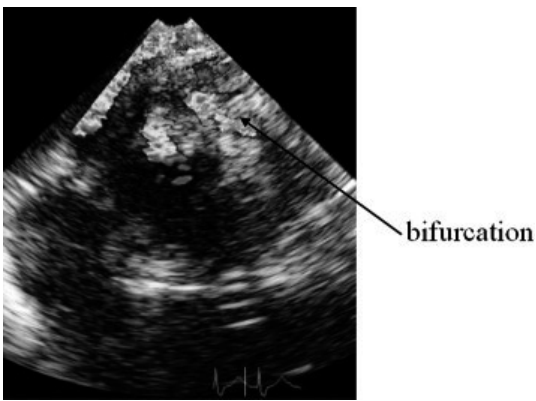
Color Doppler of the mainstem coronary artery re-implantation in the aorta.
